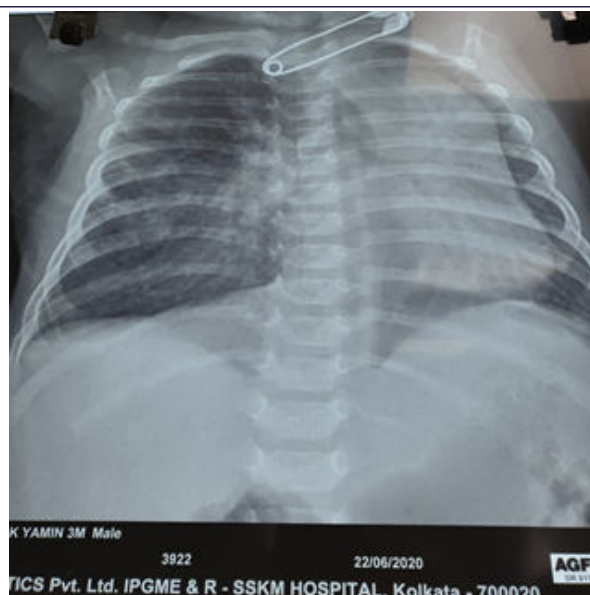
Pre-operative Chest X-ray: showing leftward displacement of heart and great vessels.
